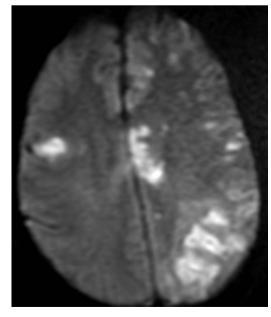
Magnetic resonance image after 5 days revealed the real extension of the embolism. A massive stroke involving both sides of the brain can be seen.
